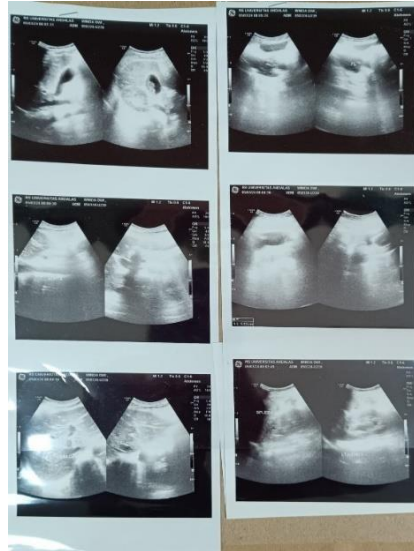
Ultrasound Finding
